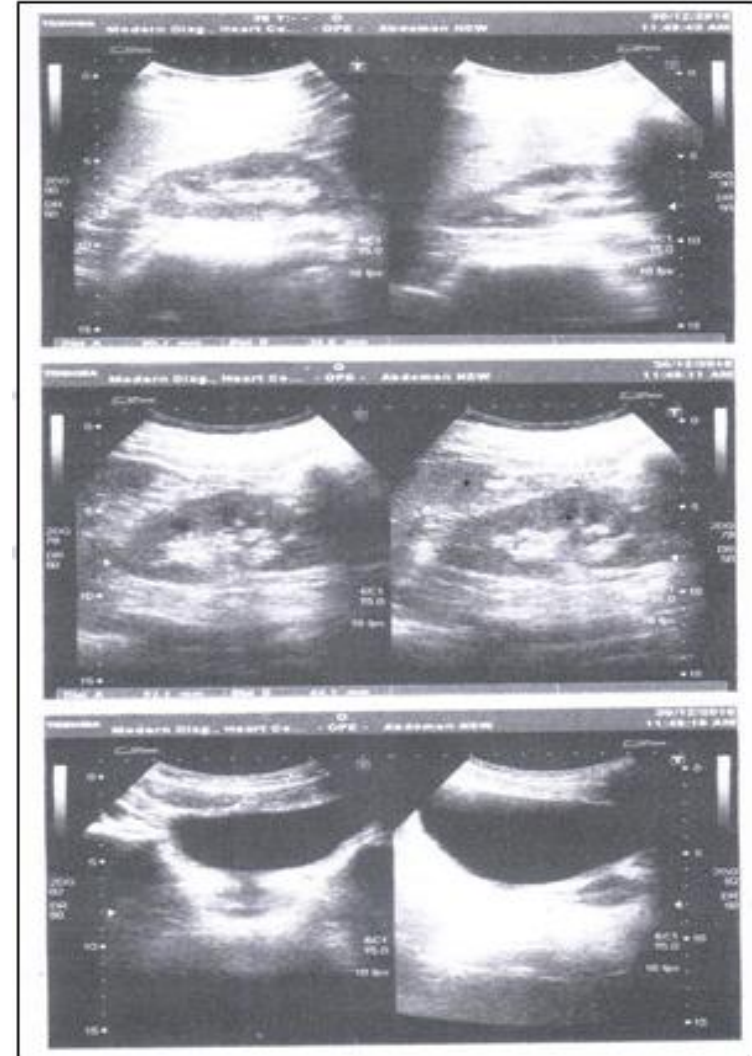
Figure 1B2: Ultrasonography Image after treatment.
